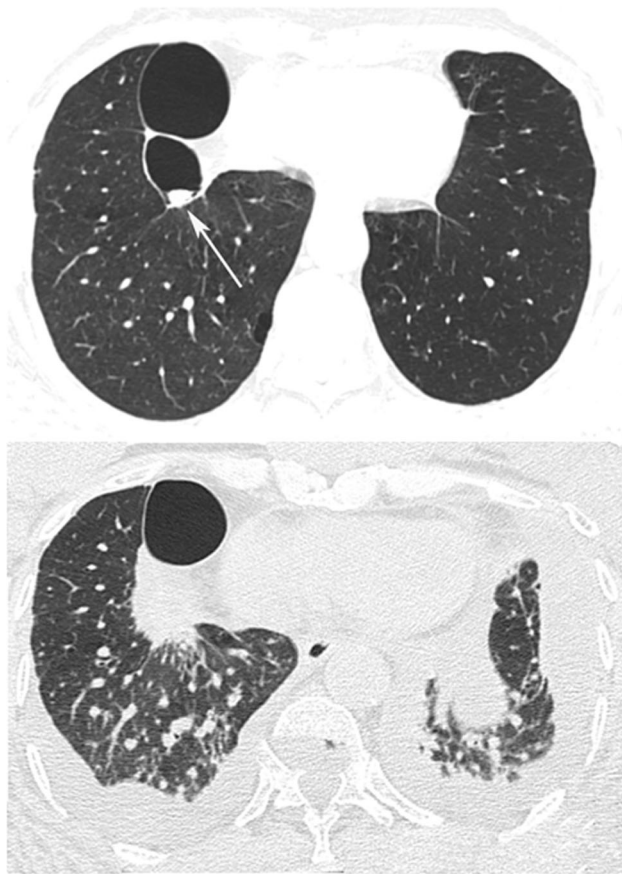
Lung cancer. A 74-year-old man with a history of pulmonary TB 50 years previously. An axial CT image (a) shows two bullae in the right lower lobe, with a small nodule inside the smaller bulla (arrow). A follow-up image obtained 2 years later (b) demonstrates a mass with spiculated borders in the posterior aspect of the largest bulla, corresponding to the growth of the small nodule seen previously inside the smaller bulla. Also note the parenchymal interstitial thickening, suggestive of carcinomatous lymphangitis, and bilateral pleural effusion
